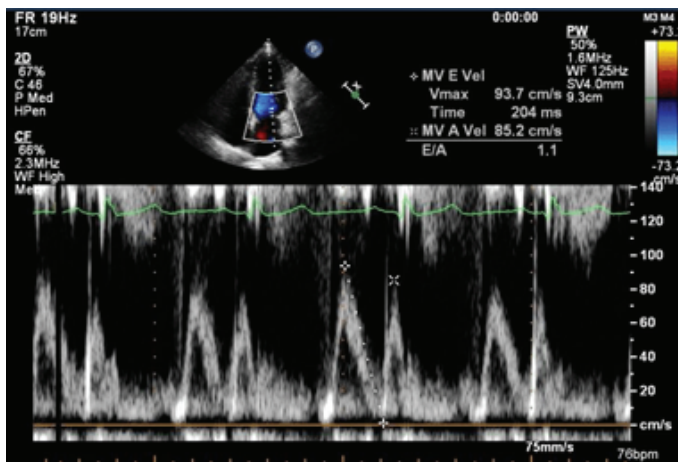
Doppler Study for measuring Diastolic Dysfunction
